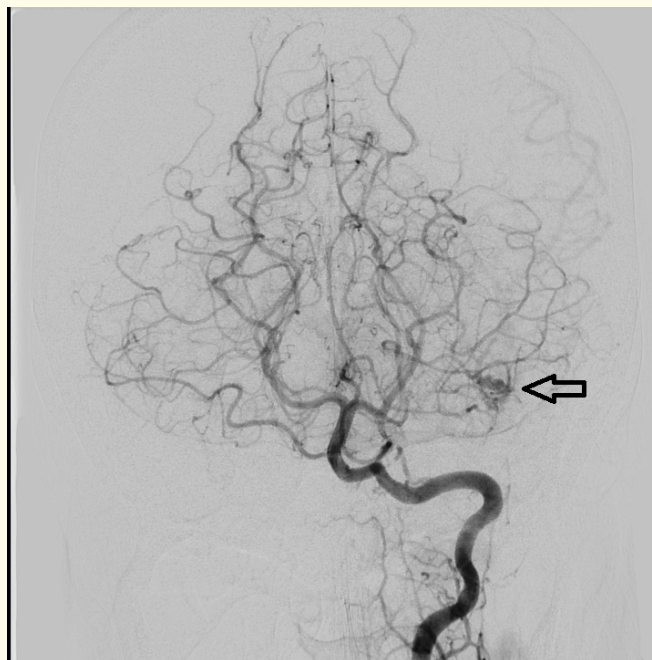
MRI axial plane (A) showed Left Anterior Temporal AVM. DSA Images Antero-posterior view (B) and Lateral view (C) showed AVM nidus (Empty Black arrow). Image (D) antero-posterior view showed deep sylvian vein draining into basal vein of Rosenthal (White bordered black arrow). Image (E) showed microcatheter taking multiple acute curves (Empty black arrow) and Tip of microcatheter just at the entrance of nidus (solid black arrow). Image (F) antero-posterior view showed EVOH cast. DSA antero-posterior view (G) and Lateral View (H) showed complete obliteration of AVM at Immediate post embolization. DSA after 3 years confirmed complete cure (Not shown here).
